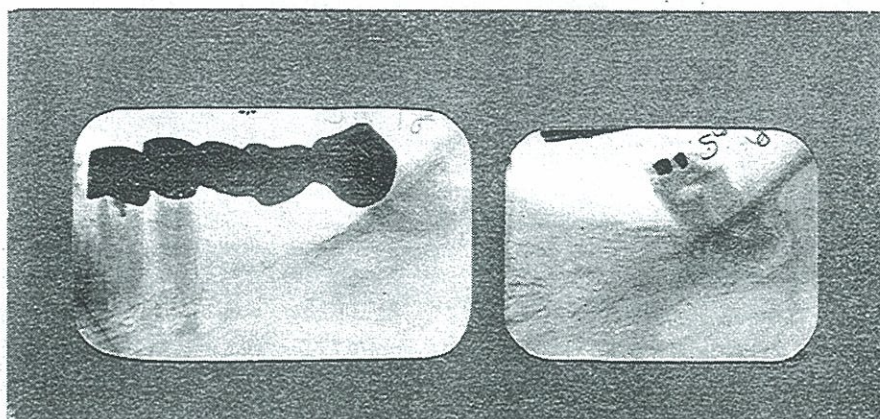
ROENTGENOGRAPHIC APPEARANCE OF A TOOTH WITH CARIES BENEATH A BRIDGE WHICH TWO YEARS LATER PRODUCED TORTICOLLIS ON OPPOSITE SIDE OF NECK OF CASE 455.
